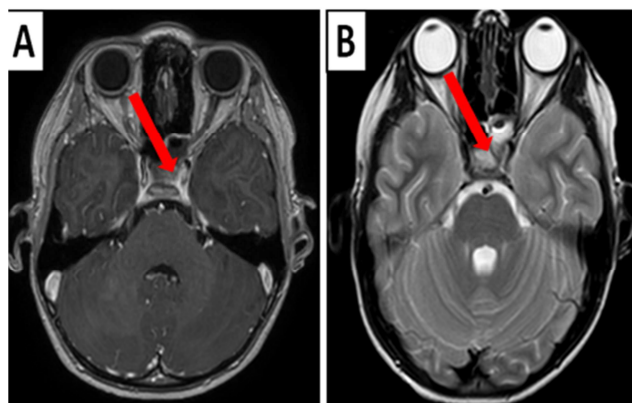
Brain Magnetic Resonance Imaging (MRI) showing sphenoid sinusitis (opacified sphenoid sinus and enhanced peripheral mucous membrane).
